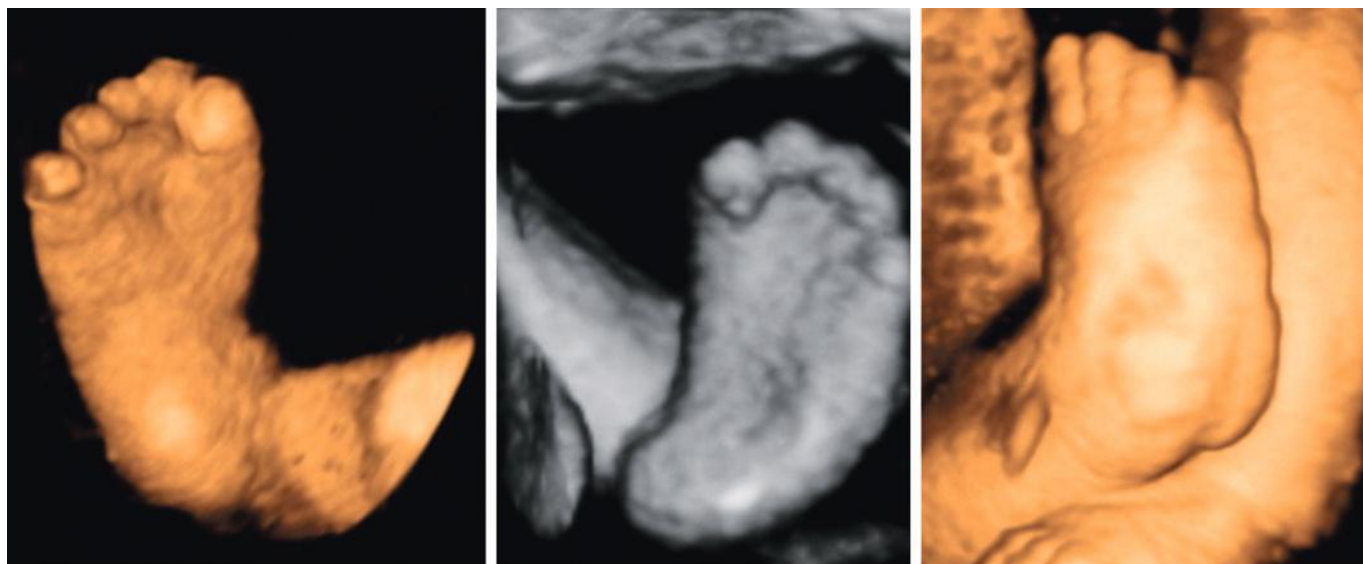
Two-dimensional ultrasound images using surface mode in a fetus with unilateral clubfoot showing internal rotation and hyperflexed toes.
